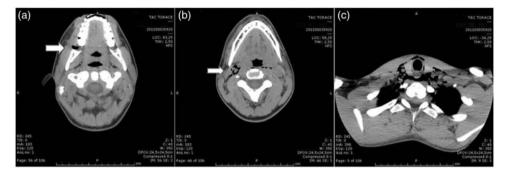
Computed tomography showing (a) air in the empty socket of the lower right third molar (arrow), (b) air in the right submandibular space (arrow), and (c) neck and upper mediastinal emphysema.
